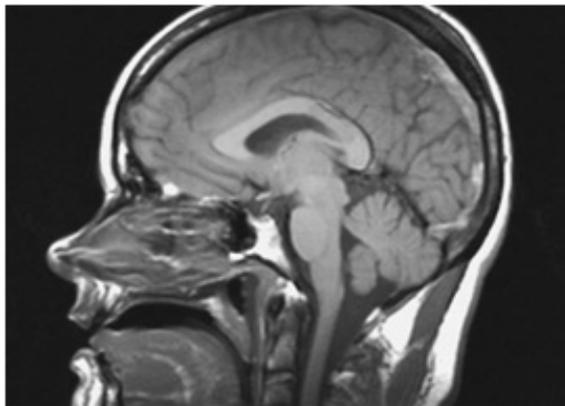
a T1-weighted MRI scan obtained with the spin-echo technique provides a sagittal view of a hyperintense signal in the thrombosed superior sagittal sinus (arrows).
